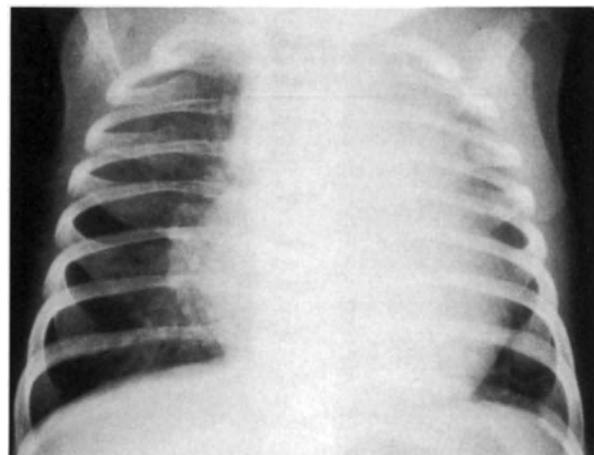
Chest radiograph in an infant with severe coarctation of the aorta. There is cardiomegaly and heart failure due to the load placed on the heart by the aortic obstruction.
